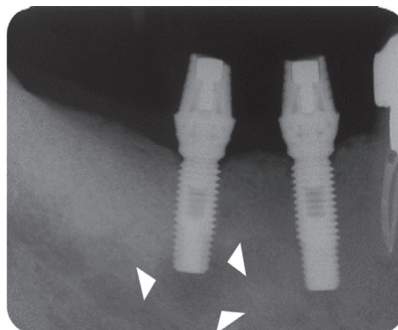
Periapical radiograph after 9 months of implant placement. Arrow heads depict the extent of IPL.
